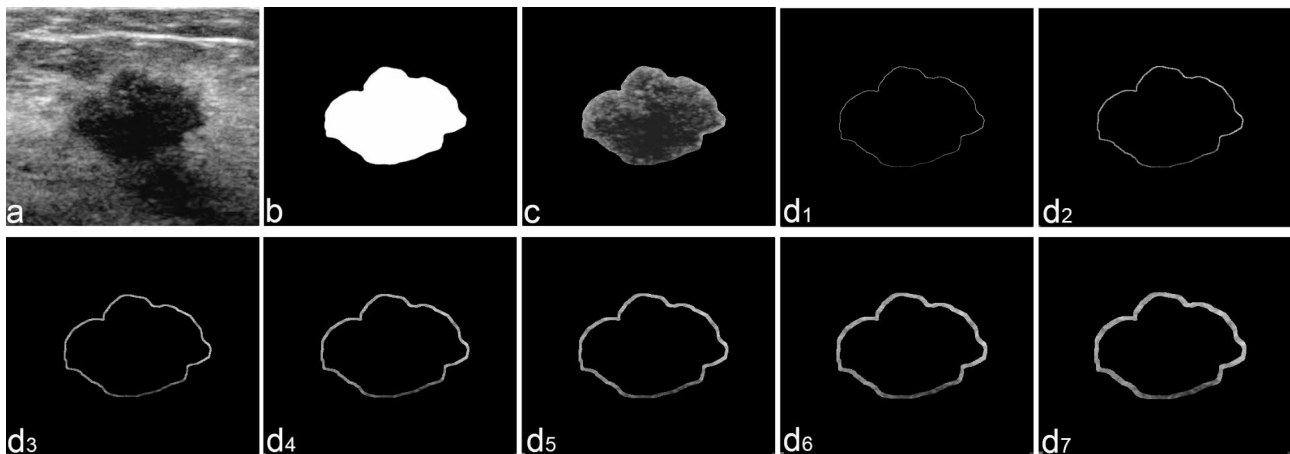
The ultrasound automatic segmentation example: a Original image of breast cancer. b Tumor mask. c Tumor region in the ultrasound image. d Peritumoral tissue with different thicknesses (1–7 pixel) in the ultrasound image
